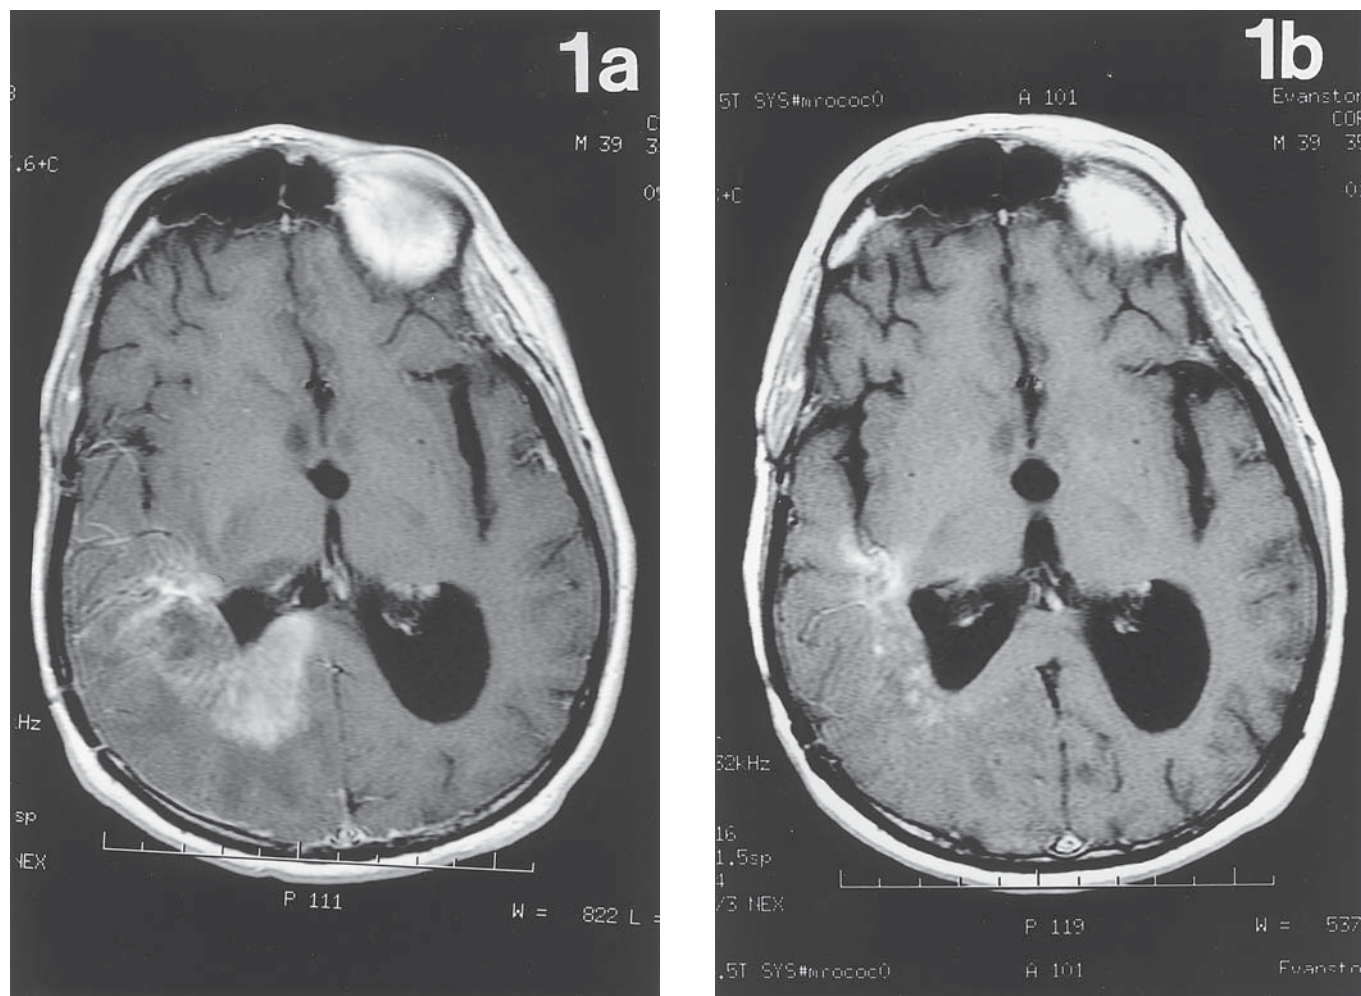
(A) MRI (T1 postgadolinium) of a patient with recurrent glioblastoma, on a low-dose (4 mg twice a day) of dexamethasone, whose symptoms were worsening. (B) MRI (T1 postgadolinium) of the same patient 8 d after increasing the dexamethasone to 20 mg twice a day. There were no other changes in management.
